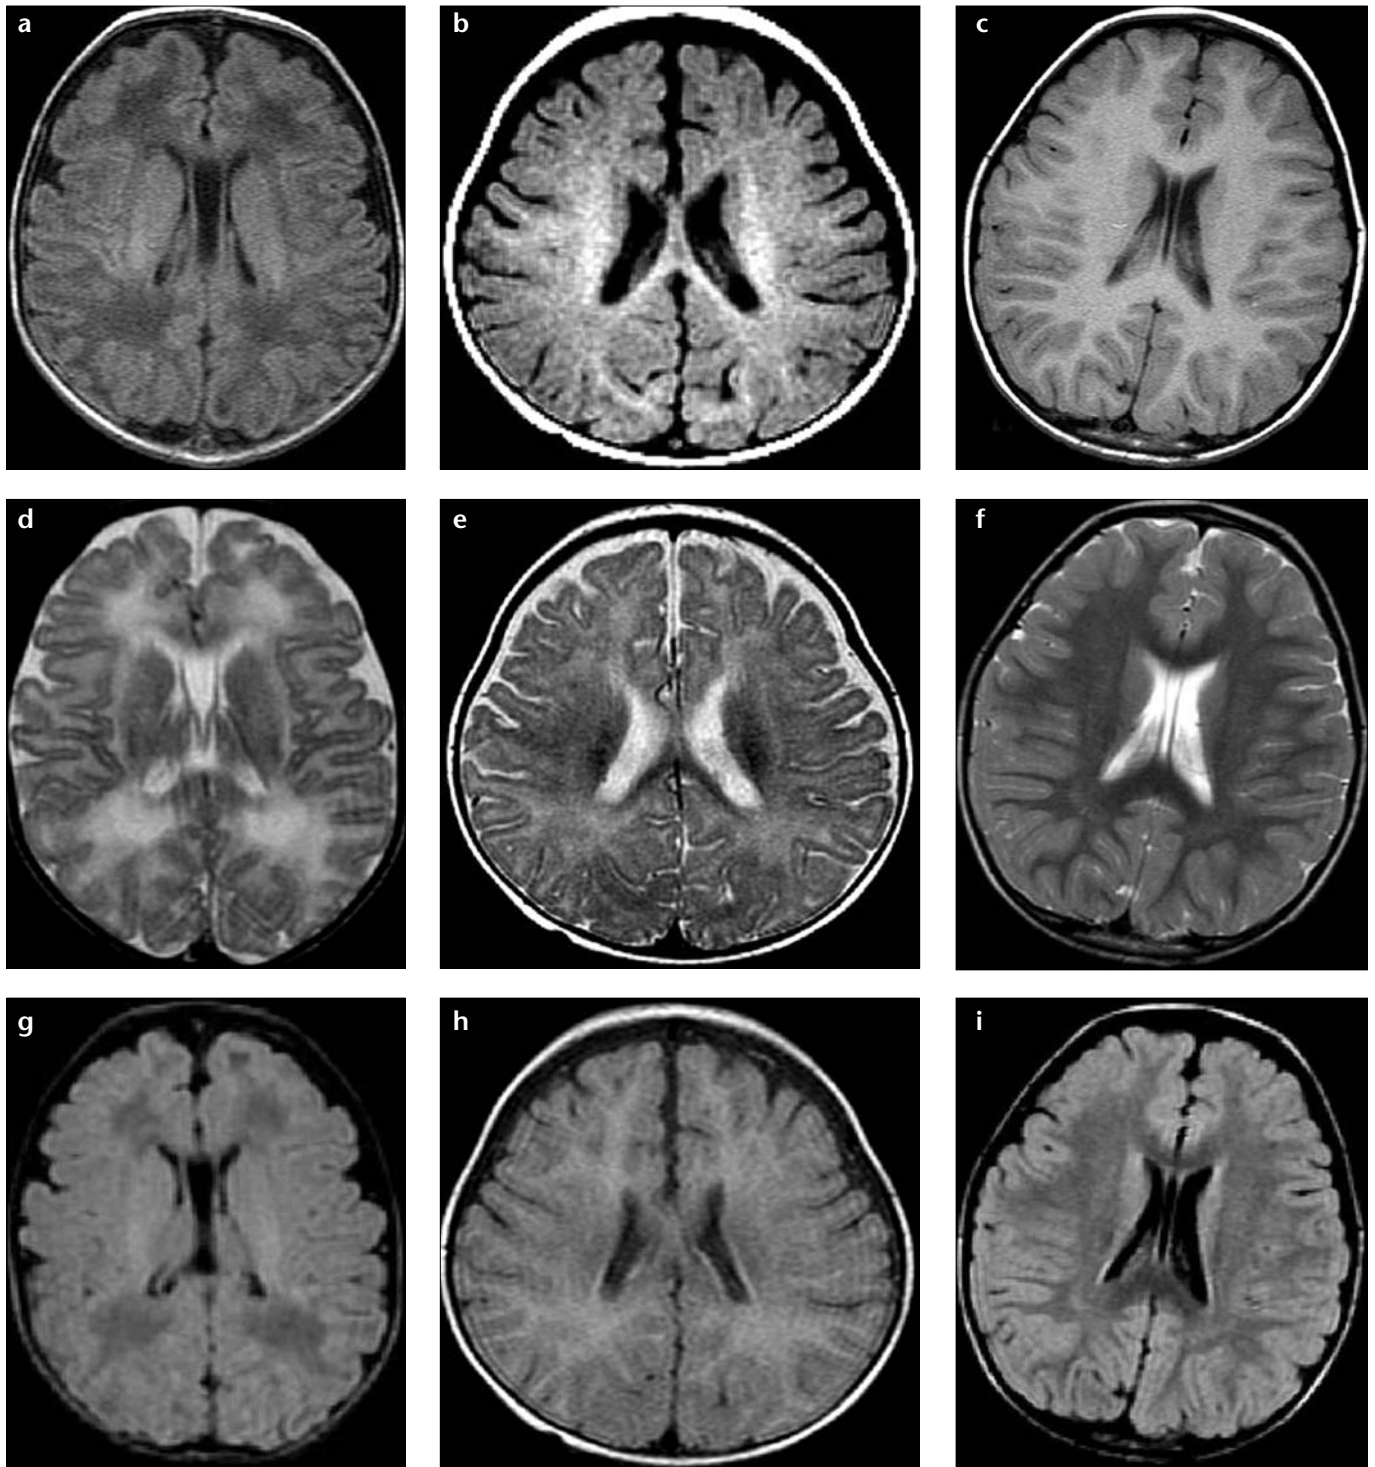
a-i. On transverse T1W (a-c), T2W (d-e), and FLAIR (g-i) images of an 8-day-old newborn (a, d, g), 6-month-old infant (b, e, h), and 25-month-old infant, signal changes in the deep white matter of the occipital and frontal lobes were visualized. The cerebral white matter in the newborn was hypointense on the T1W image (a) and later became hyperintense in the sixth month (b) and the twenty-fifth month (c). These regions were hyperintense on T2W images in the newborn (d) and the 6-month-old infant (e), and hypointense in the 25-month-old infant (f). On FLAIR images, the mentioned white matter areas were hypointense in the newborn period (g), similar to the T1W image, and demonstrated hyperintensity at the sixth month of age (h), and became hypointense again at the twenty-fifth month of age (i).
